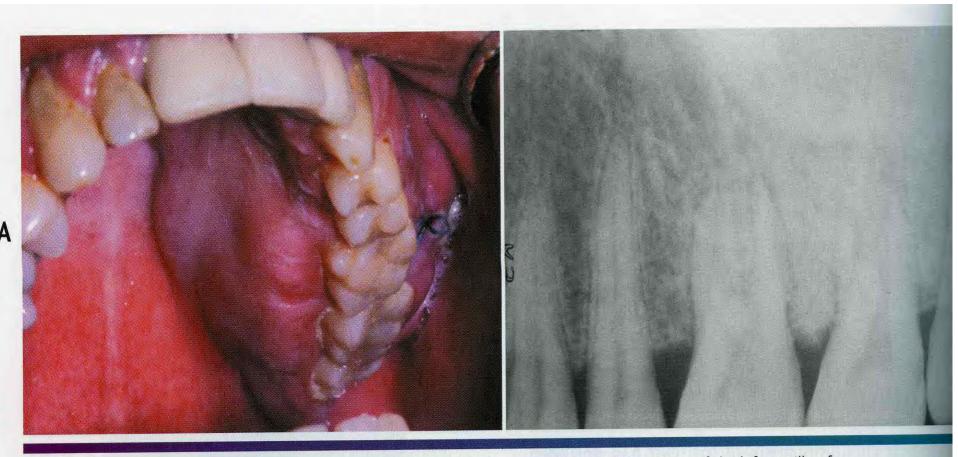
• Osteosarcoma. A, This patient shows a firm, painful swelling of the left maxilla of recent onset. B, The periapical radiograph shows a dense sclerotic change in the bone pattern. (Courtesy of Dr. Len Morrow.)
